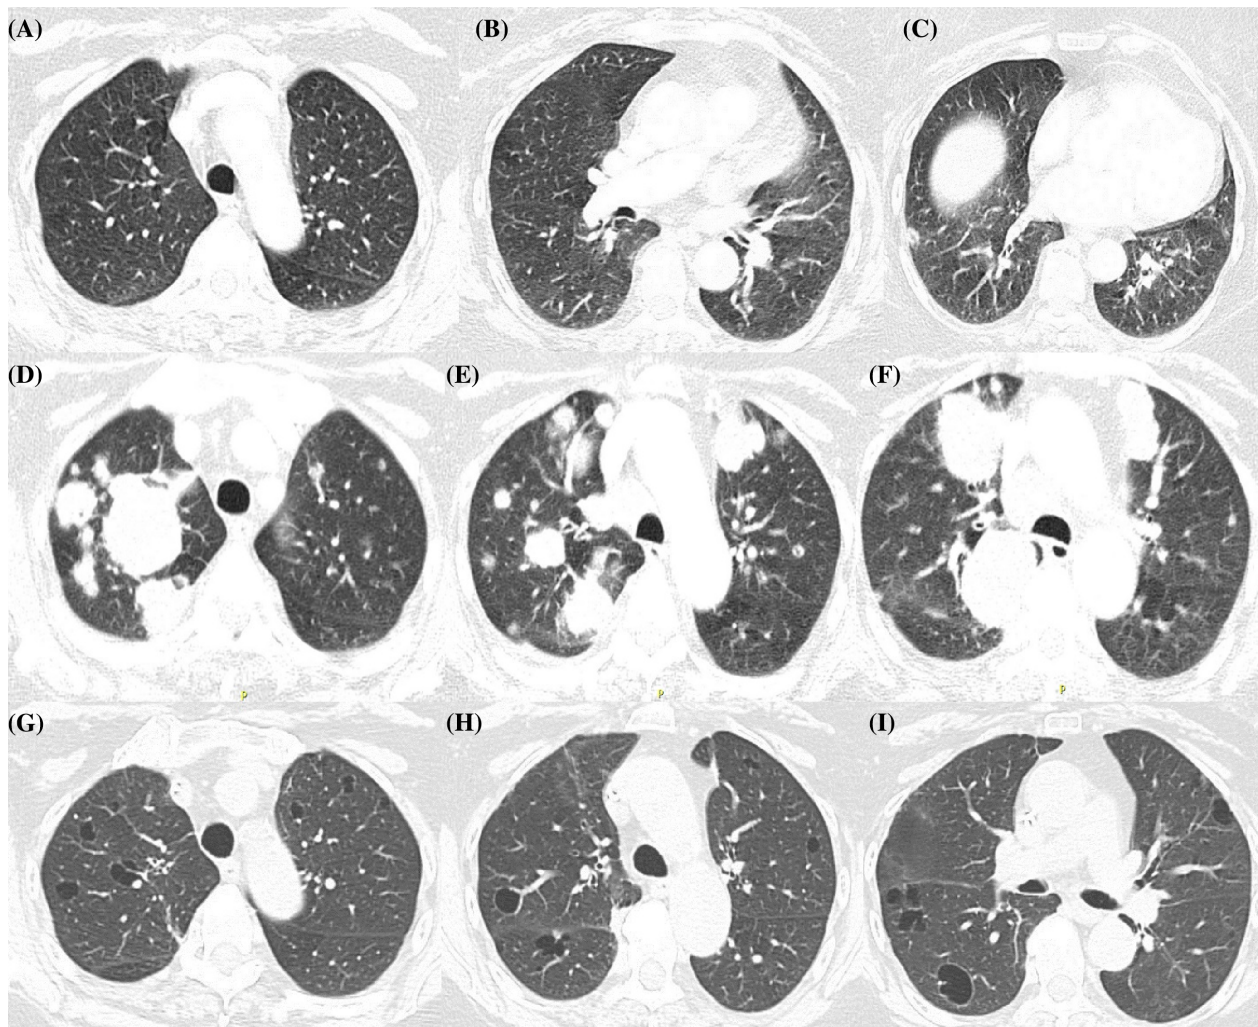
(A) CT chest of the upper lung field shows normal parenchyma with no metastatic or cystic lung disease appreciated. (B) CT chest of the mid lung field shows normal parenchyma with no metastatic or cystic lung disease appreciated. (C) CT chest of the lower lung field showing subpleural solitary nodular opacity of the right lower lobe (metastatic endometrial carcinoma). No pulmonary cysts, or any other pathological findings noted. (D) CT chest of the upper lung field shows numerous solid masses and nodules throughout both lungs of variable size and shape and random distribution, conglomerate mass in the right apex. (E) CT chest of the upper lung field shows numerous solid masses and nodules throughout both lungs of variable size and shape and random distribution. (F) CT chest of the upper lung field and the superior segments of lower lobes bilateral shows a few solid masses and nodules throughout both lungs of variable size and shape and random distribution. The right lower lobe superior segment mass measuring 4.9×3.8 cm (red arrow). (G) CT chest of the upper lung field, status post treatment with Taxol based chemotherapy and Bevacizumab. shows resolution of pulmonary metastasis and bilateral asymmetrical cystic lung disease, of variable size, shape, air filled, with well-defined thin walls, anatomically related to a previously noted endometrial metastatic lesions. (H) CT chest of the upper and lower lung field, status post treatment with Taxol based chemotherapy and Bevacizumab, shows resolution of pulmonary metastasis and a new onset bilateral asymmetrical cystic lung disease, of variable size, shape, air filled, with well-defined thin walls, anatomically related to a previously noted endometrial metastatic lesions. (I) CT chest of the right middle lobe, lingula along with partial upper and lower lobes, status post treatment with Taxol based chemotherapy and Bevacizumab. shows resolution of pulmonary metastasis and a new onset bilateral asymmetrical cystic lung disease, of variable size, shape, air filled, with well-defined thin walls, anatomically related to a previously noted endometrial metastatic lesions.
